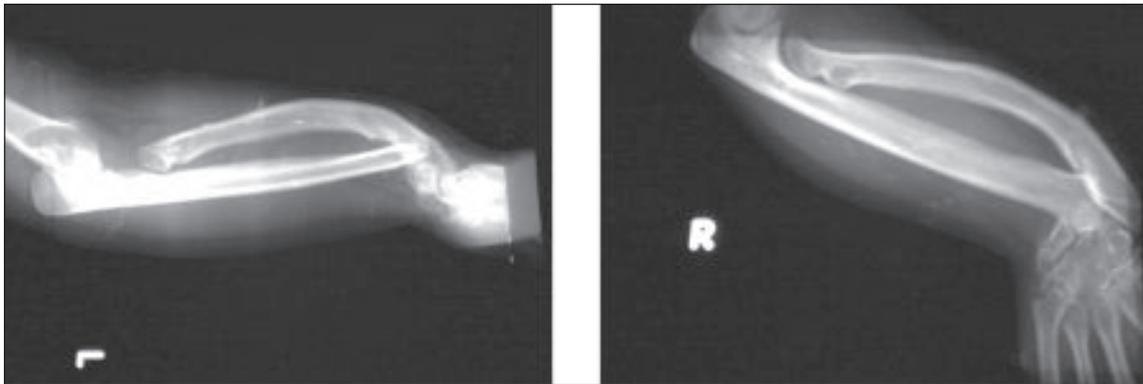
X-ray of hand and wrist shows palmar carpal distance 21 mm and dorsal & radial bowing of radius with exaggerated radial inclination.
